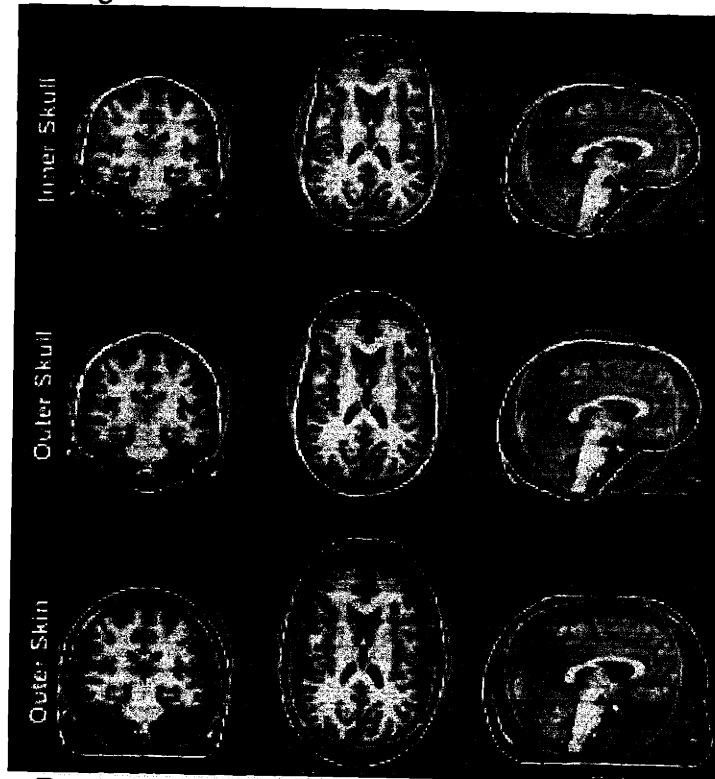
Resistivity Boundaries. The inner skull, outer skull and outer skin are overlaid (yellow) in three orthogonal views of the T1-weighted MR volume. The spherical estimates of the inner skull, outer skull and outer skin are overlaid in green.
